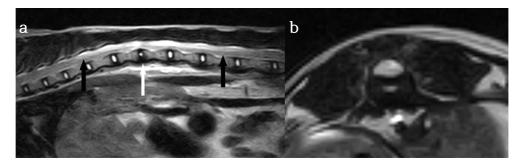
Magnetic resonance images. (a) Sagittal T2-weighted image showing disc protrusion at the level of T12-T13 (white arrow). The spinal cord from T10 to L2 had hyperintensity indicates spinal contusion (black arrows). (b) Transverse T2-weighted image with cross-sectional area of the spinal cord at the level of maximal dorsal compression (T12-T13).
